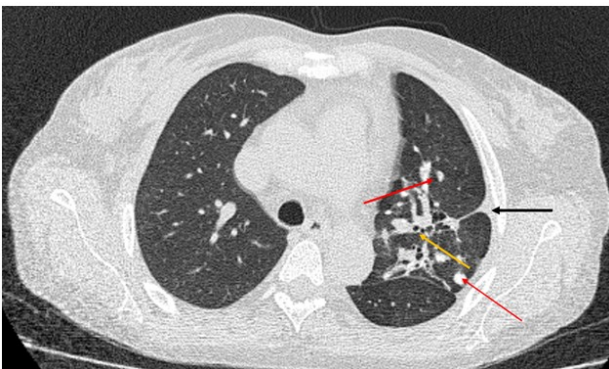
Computed tomography in the axial in lung window. The image show multiple solid nodules with well-defined margins (red arrows), bronchiectasis (yellow arrow) associated with subsegmental atelectasis (black arrow), in contact with a thickened pleura
